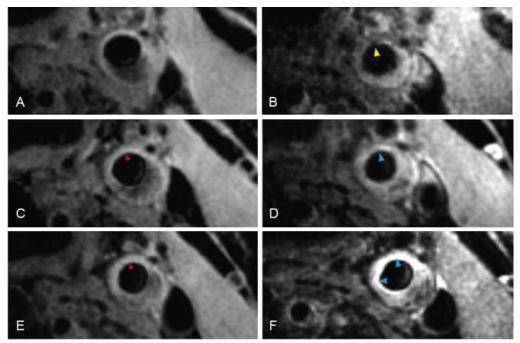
T2*-weighted imaging of a left common carotid artery before and after ultrasmall superparamagnetic iron oxide (USPIO) infusion at the three time points of 0 (A and B), 6 (C and D), and 12 weeks (E and F). B, USPIO uptake can clearly be seen in the plaque at baseline (arrowhead). C and E, Pre-USPIO imaging remains similar at all three time points with Sinerem having been cycled out of the plaque before reimaging (arrowhead). D, The plaque begins to enhance at 6 weeks (arrowhead). This signifies that there is a predominant T1 effect, indicating minimal USPIO uptake and a lack of activated macrophages (minimal inflammation). E, No residual USPIO signal is also seen in the pre-USPIO imaging at 12 weeks. F, Signal enhancement post-USPIO can be seen with no evidence of signal voids (arrowheads). (Modified from Tang TY, Howarth SPS, Miller SR, et al: The ATHEROMA [Atorvastatin Therapy: Effects on Reduction of Macrophage Activity] Study. Evaluation using ultrasmall superparamagnetic iron oxide-enhanced magnetic resonance imaging in carotid disease. J Am Coll Cardiol 53:2039, 2009.)
